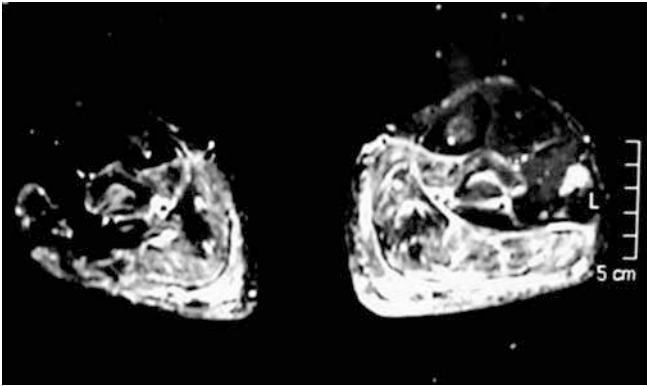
MRI (T₂-weighted image) findings of the lower leg muscles on admission. Both lower leg muscles showed an increased signal around soleus and gastrocnemius muscles, and the swelling of the fascia of these muscles
